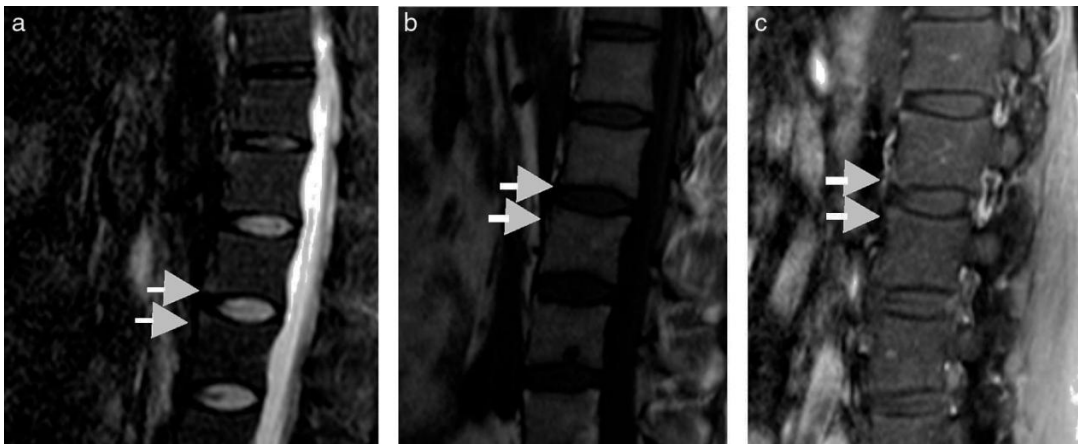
MRI. Very initial and subtle Romanus lesion on the anterior margins of the lumbar vertebral bodies. In the first image (a), indicated by white arrowheads, a STIR sequence is shown, small ~ hyperintense borders, representing edema in anterior aspects of multiple lumbar vertebrae, which correspond to the images on the right: a T1 without contrast (b), where slight hypointensities are observed and enhancement with the use of contrast medium in T1 fat sat sequence (c)
